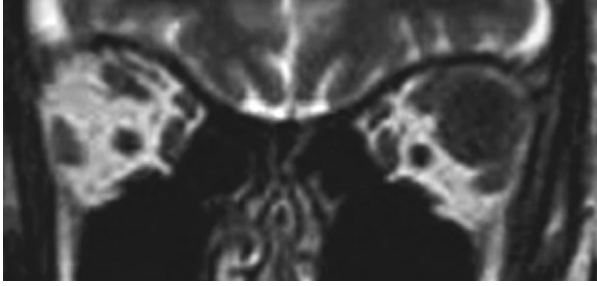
On T₂-weighted MRI scan, the lesion remains hypointense.
